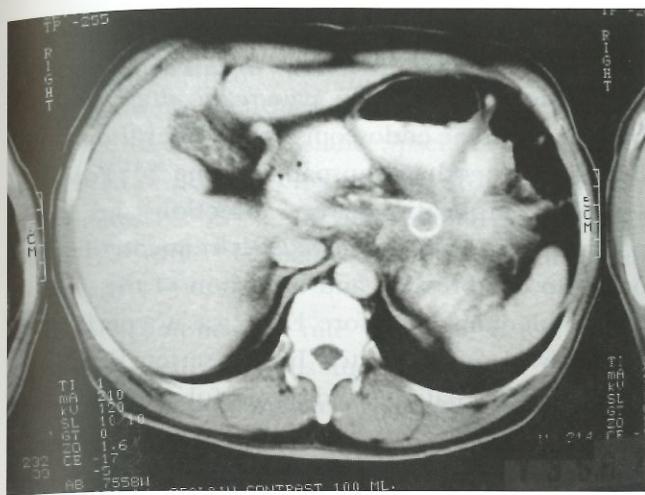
Repeated abdominal CT in patient #7, 3 months post endoscopic cystenterostomy, showing resolution of the pseudocyst
